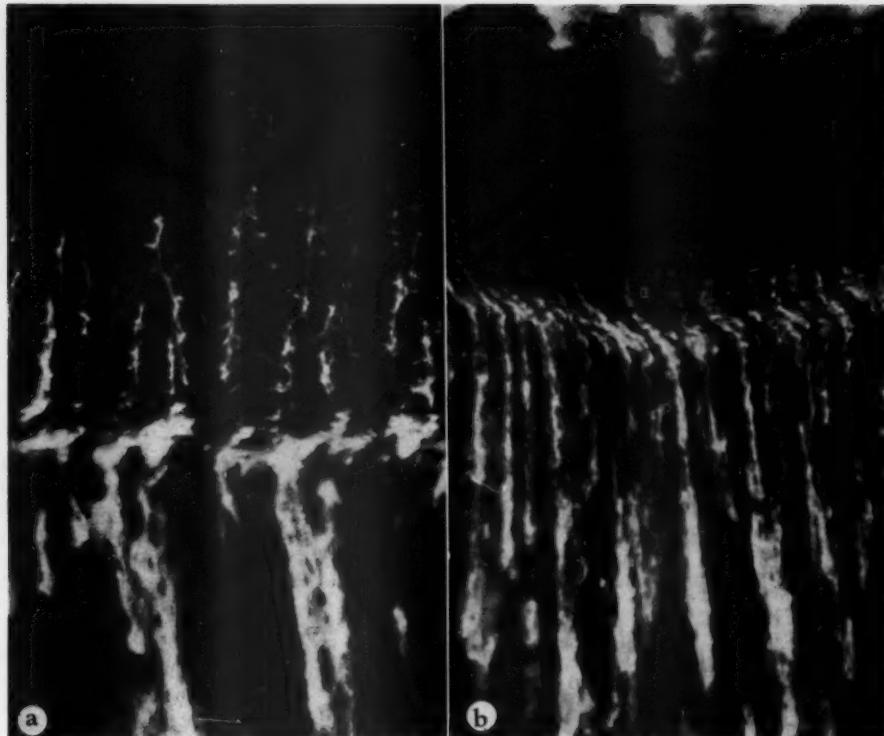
Soft-x-ray technique for demonstrating mineral salts in ground sections, showing the changes of the mineralized trabeculae of costal (a) and metatarsal (b) metaphyses 48 hours after injection. Reduced to $\frac{3}{4}$ of mag. $\times 256$.
